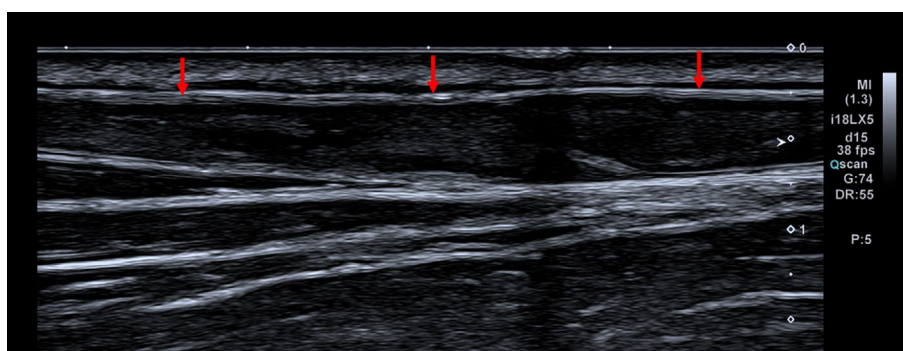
Ultrasonography of the vein in the left forearm. We found a thrombus extending from the radial vein up to the distal brachial vein. On pressing with an echo probe, the blood vessels did not collapse. Similar findings were also found on the right forearm.
